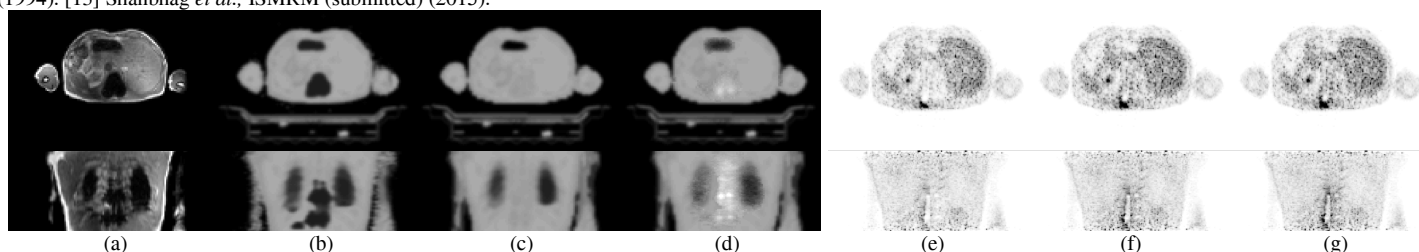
(a) In-phase MR image, (b) MR segmentation based attenuation map without any anatomical prior knowledge, (c) MR segmentation based attenuation map with anatomical prior knowledge, (d) attenuation map with uncertain regions resolved by selective-update joint estimation; and (e-g) PET images reconstructed by TOF OSEM using the attenuation maps in (b-d), respectively.
